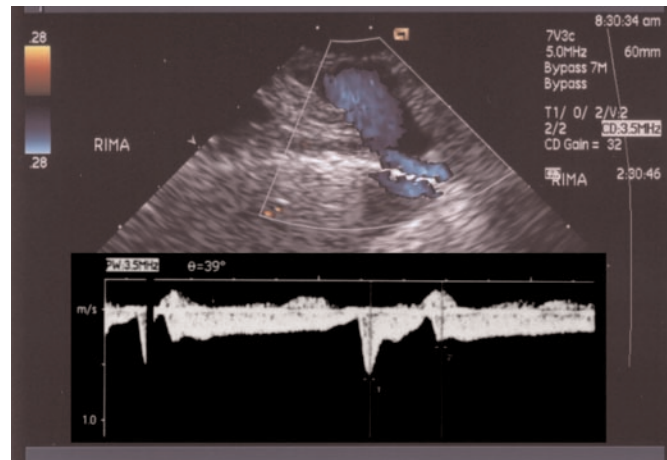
Doppler ultrasound control analysis of both internal thoracic arteries shows a good diastolic flow.
